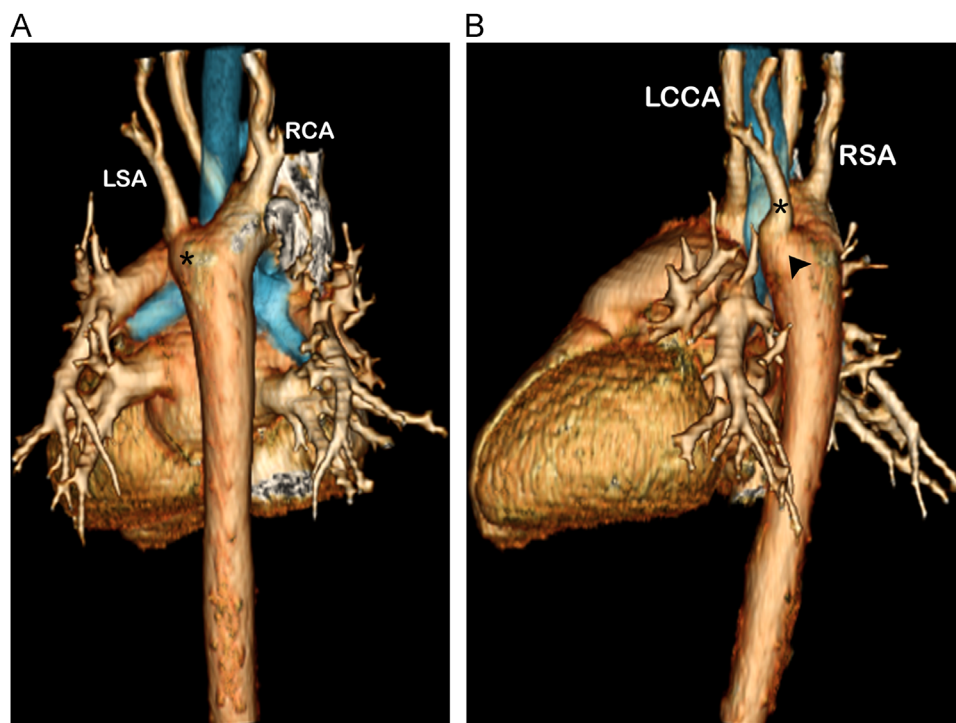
CT images from an 8-year-old boy who presented with recurrent dyspnea on exertion and a chronic cough. He has a right aortic arch, retroesophageal left subclavian artery, and a Kommerell diverticulum (*). The patient underwent left ligamentum division 18 months earlier at another institution. CT images show a large Kommerell diverticulum serving as the origin of the left subclavian artery (A). This is compressing his esophagus and trachea independently, despite prior ligamentum ligation and division (B). LCCA, left common carotid artery; LSA, left subclavian artery; RCA, right carotid artery; RSA, right subclavian artery.
